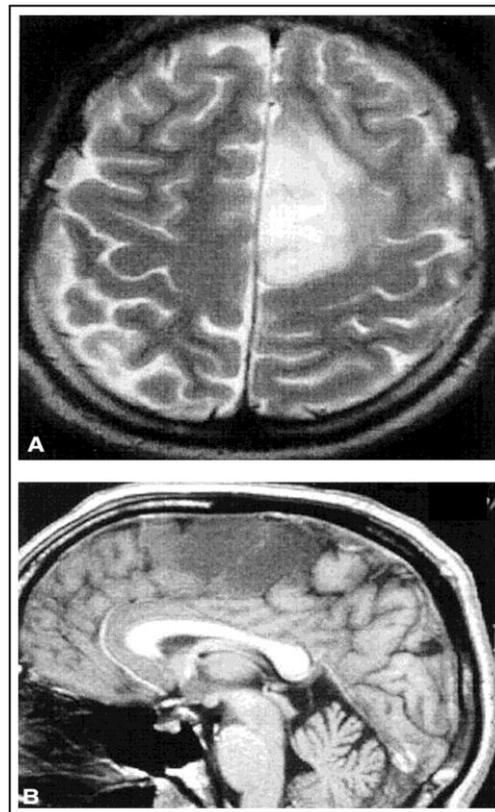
(A): T2weighted axial magnetic resonance image (MRI) and Figure 2(B): A sagittal T1weighted MRI reveals a "typical" left frontonasal, precentral, low-grade glioma of the supplementary motor region.
